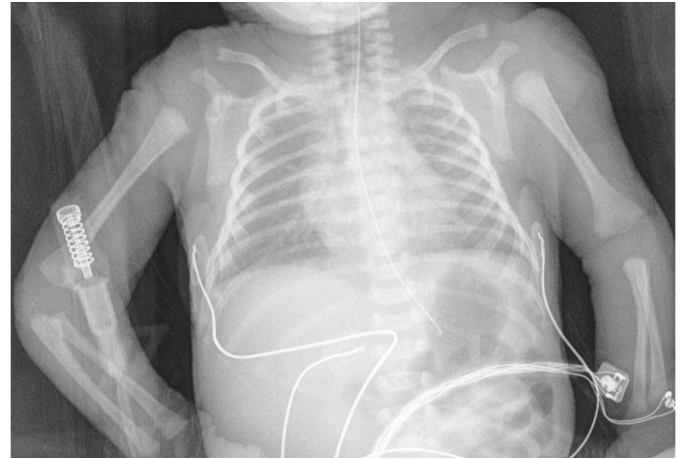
An anteroposterior chest radiography obtained on day 1 did not reveal any acute osteoarticular lesion.
